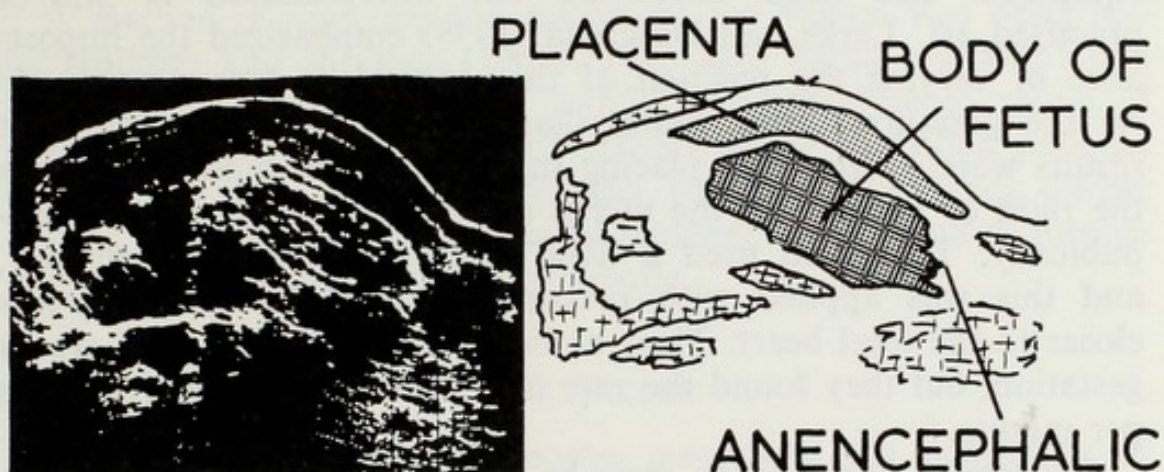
Longitudinal ultrasound scan: anencephalic fetus.
